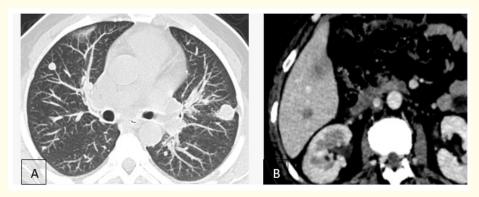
Contrast enhanced CT scan in axial section showing pulmonary (A) and hepatic (B) metastatic.
